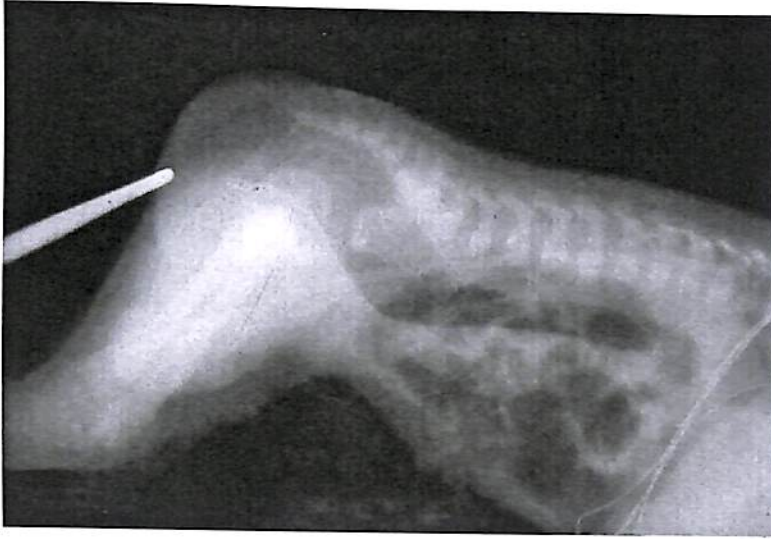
Lateral cross table radiograph with the baby in the prone position to detect high or low type of ARM.
